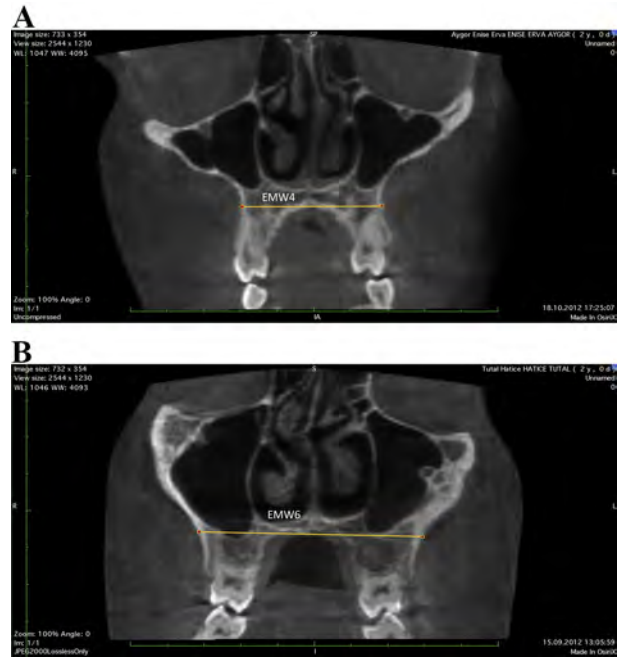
Skeletal measurements on cone-beam computed tomographic images: External maxillary width (EMW) at the level of center of the right maxillary first premolar root (A) and the right maxillary first molar furcation (B).
